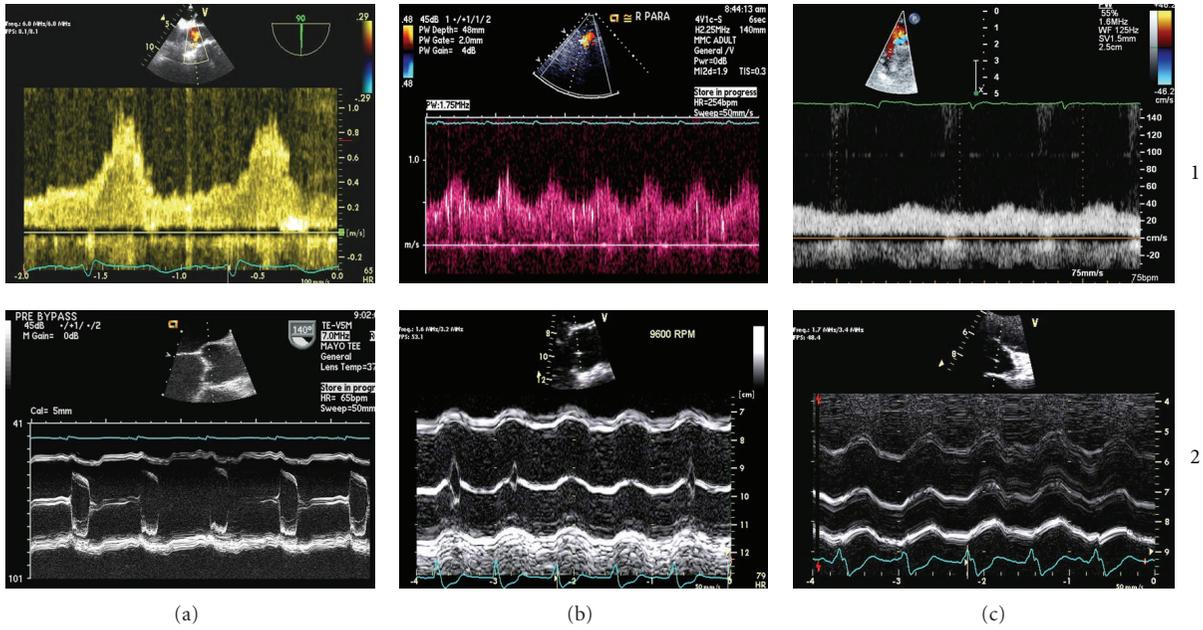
LVAD speed settings. Columns: (a) minimal speed; (b) submaximal speed; (c) maximal speed. Rows: (1) pulsed Doppler, outflow cannula; (2) M mode aortic valve. The status of aortic valve opening and aortic flow pulsatility depends on pump speed and output, LV contractility, preload, and afterload conditions. Reduction in LVAD speed to minimum will result in minimal unloading of the LV, increased LV systolic pressure above aortic pressure allowing pulsatile flow (a1), aortic valve opening during every cycle, seen in M mode (a2). Increasing the speed to submaximal, will unload the ventricle, reduce systolic left ventricular pressure, decrease the outflow pulsatility (b1), and result in intermittent aortic valve opening in M mode (b2). Increasing speed to maximum will unload the left ventricle even further, resulting in almost continuous aortic flow (c1), and no aortic valve opening (c2).
